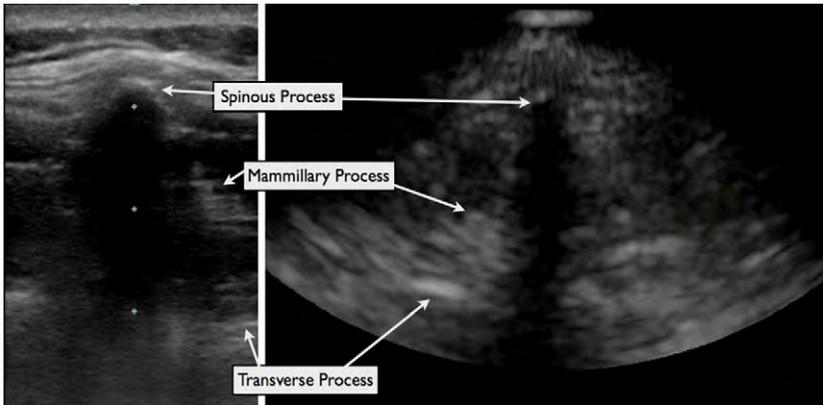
The midline of the spine on ultrasound imaging in the transverse view. The left image is with use of a high-frequency probe, and the right image is with use of a low-frequency probe.
